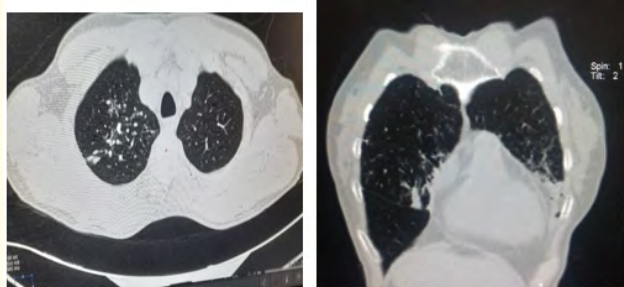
CT images showing mediastinal nodes, bilateral pulmonary infiltration. Basal Infiltration.
